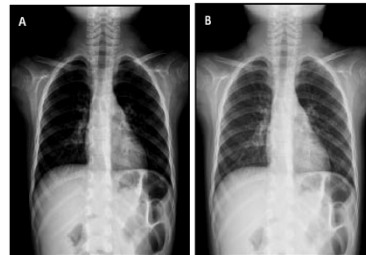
(A) Inappropriate processing of pediatric digital radiography image by vendor-supplied parameters suitable for adults. (B) Image processed by parameters modified by the customer. Images acquired on GE DR system (GE Medical Systems, Milwaukee, WI).
